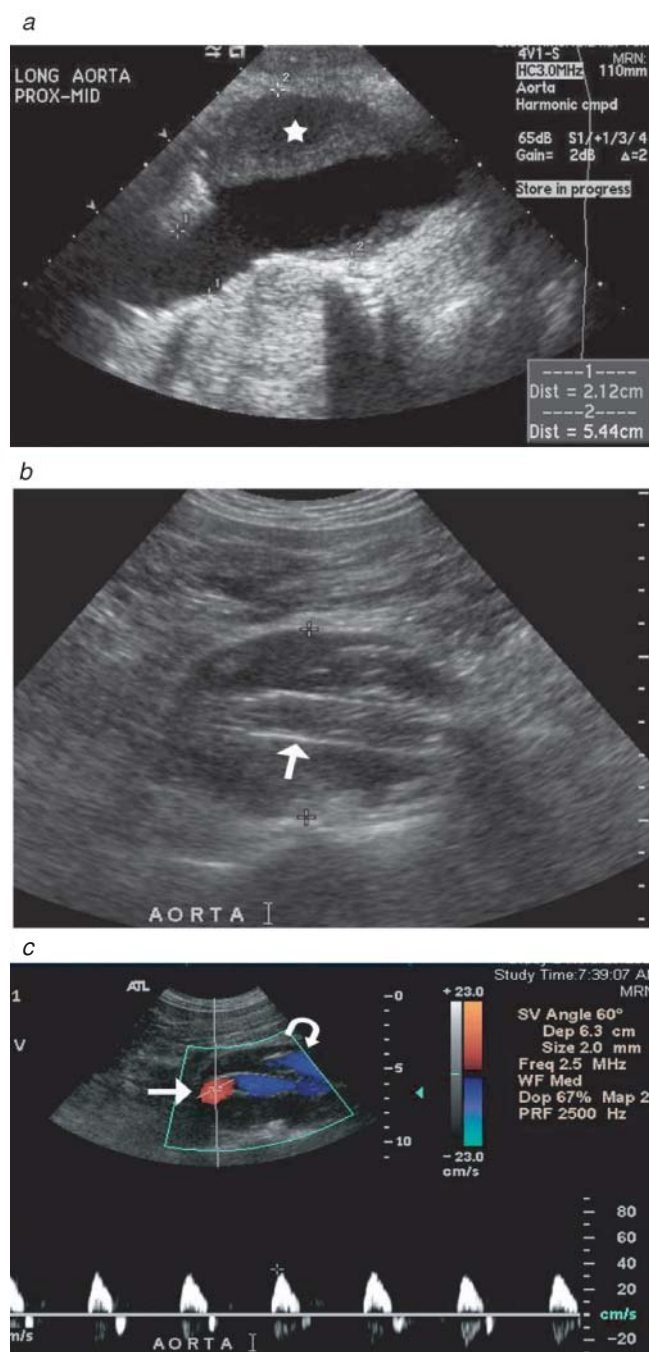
A 59-year-old male smoker underwent aneurysm screening ultrasonography. (a) A longitudinal view demonstrates a 5.5 cm infrarenal abdominal aortic aneurysm with thrombus (star) within the sac. (b) Ultrasonography was used for follow-up post-endovascular aneurysm repair. Note the stent graft (arrow) excluding the aneurysmal sac with an overall reduction in sac size compared with the initial sonogram. (c) A color duplex sonogram demonstrates patency of the main body of the stent graft (arrow) and the contralateral iliac limb (curved arrow). No endoleak was identified on this surveillance duplex ultrasound examination.
